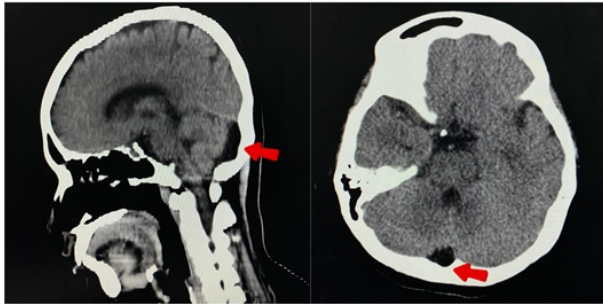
Contrast-enhanced brain CT scan identified an arachnoid cyst in the posterior fossa
